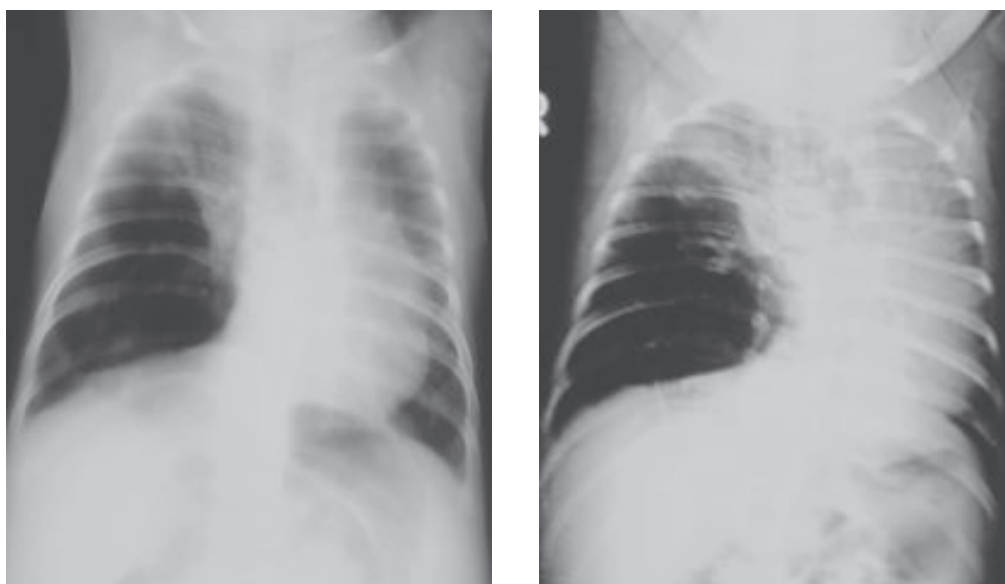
X-ray Chest P/A view (pre-operative)
